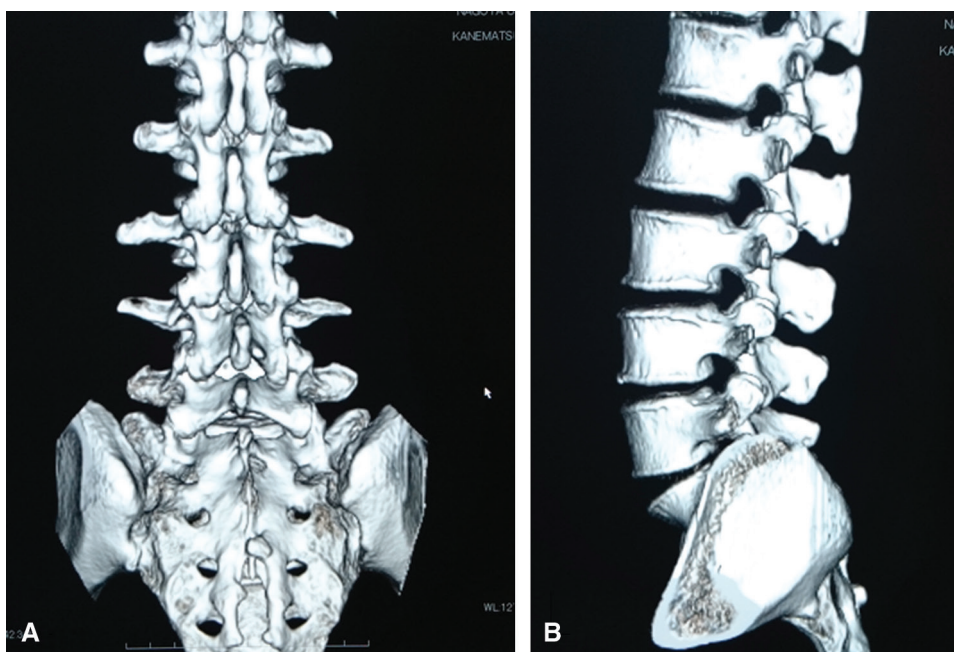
CT of lumbosacral spine did not show any congenital bone anomaly. (A) AP view and (B) lateral view. CT: computed tomography.
